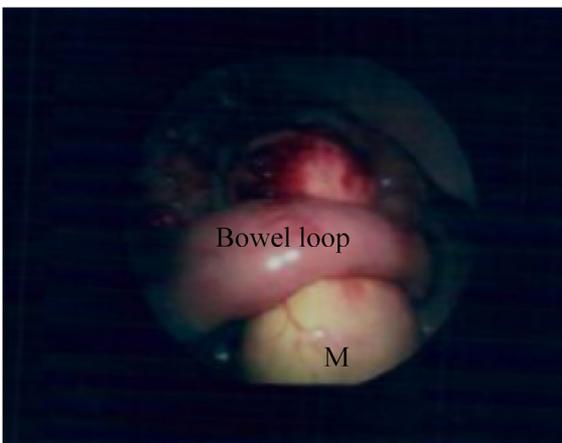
Abdominal computed tomography demonstrated (A) mesenteric mass (pointed by double arrowhead) in the left upper abdomen with (B) collapsed regional bowel loops (Bo) and (C) surgical intervention revealed intestinal adhesion with internal herniation with bowel strangulation related to the mesenteric tumor (M).
